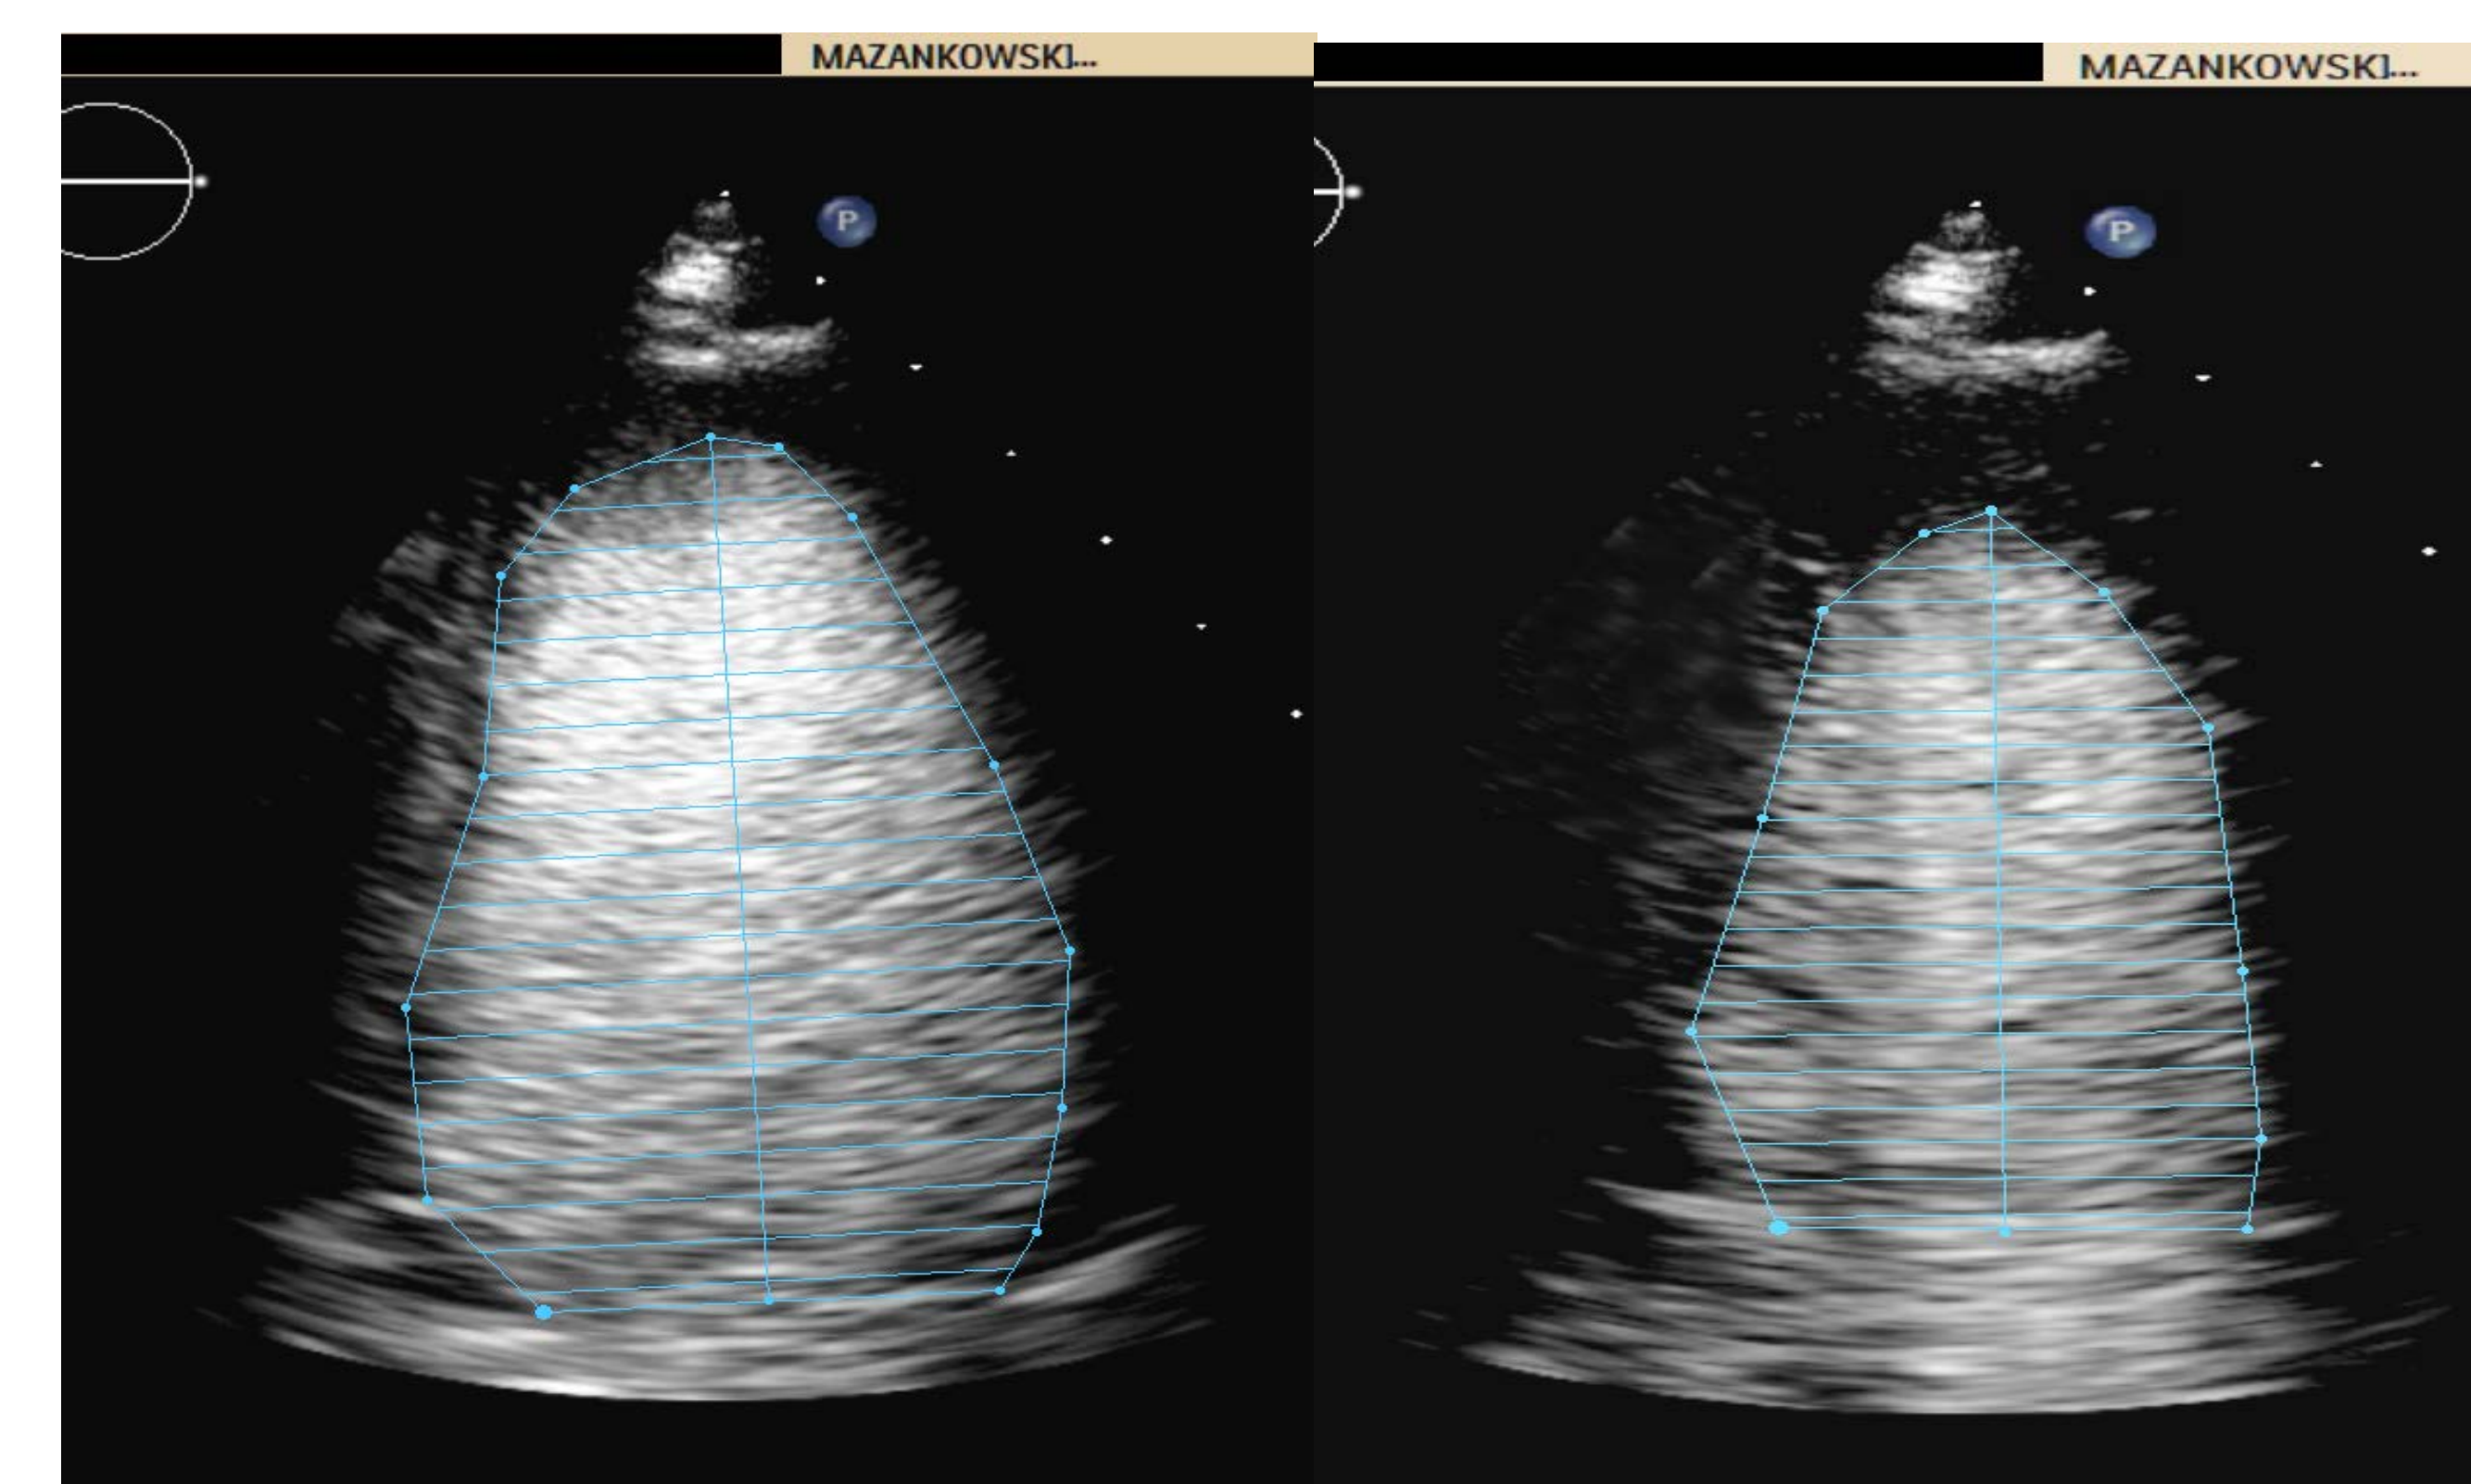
Apical 2Ch of CE-2DE in the end diastole and systole
